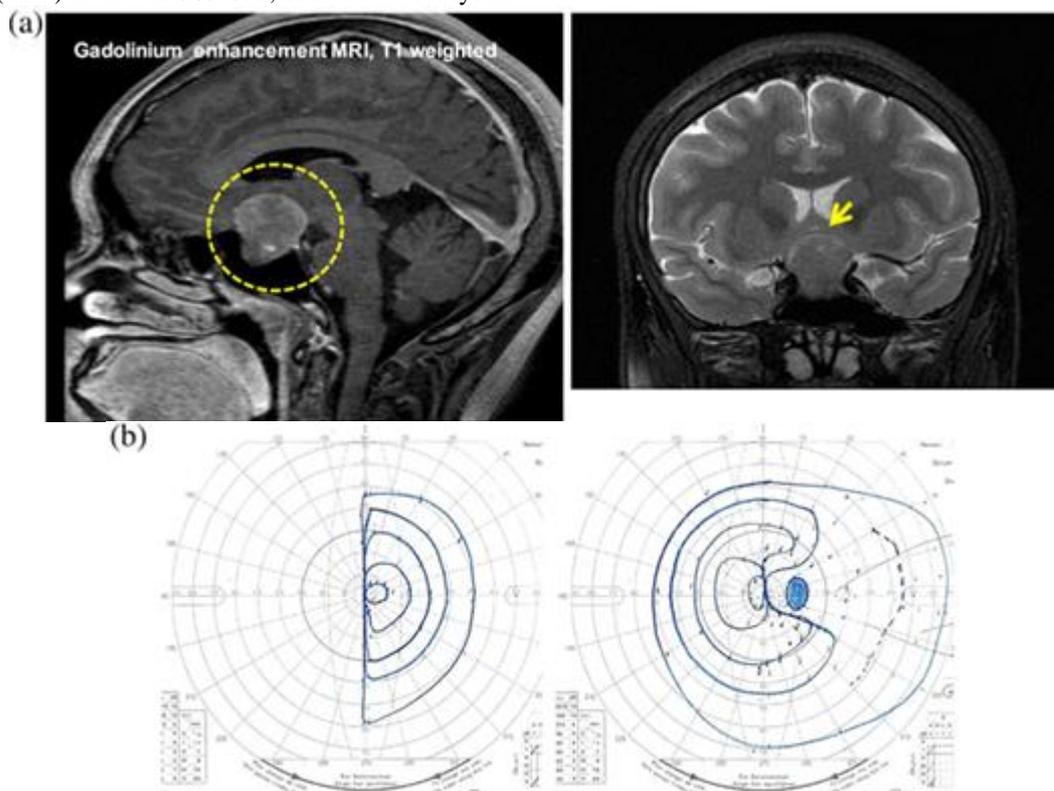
(a) Magnetic resonance imaging with gadolinium enhancement (T1-weighted). Yellow circle indicates the heterogeneously enhanced macroadenoma in the sella turcica. Yellow arrow indicates the optic chiasm compressed by the tumor (b) Visual field test (Goldmann visual field perimetry).
